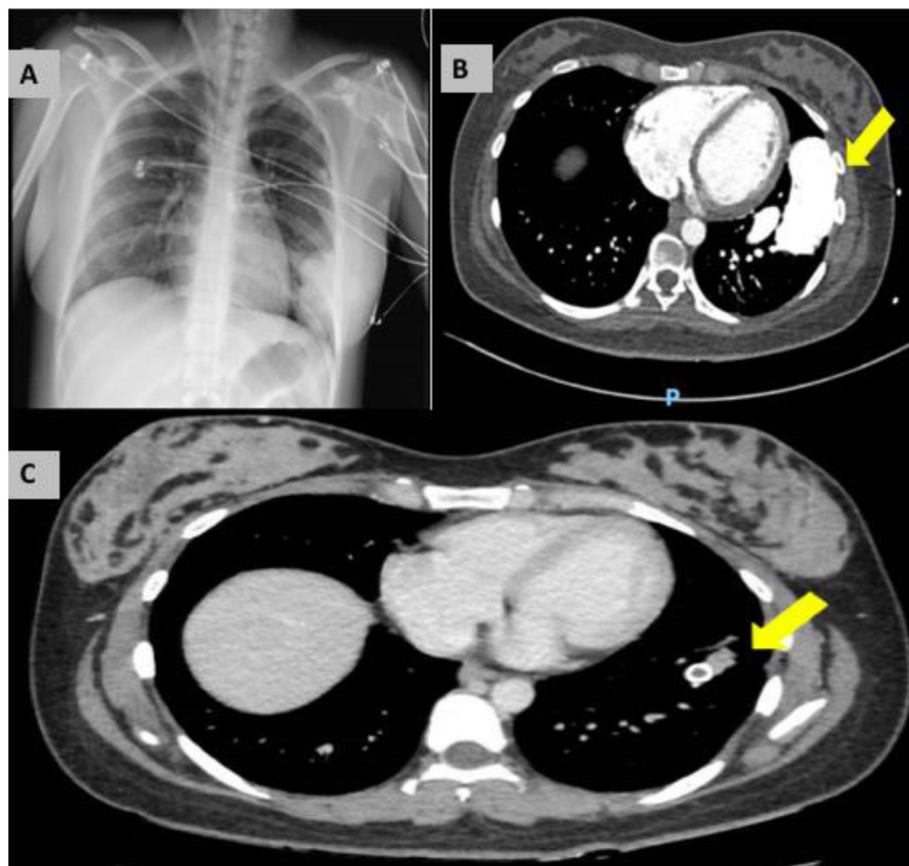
Chest X-ray showing an opacity in the left lower lobe. (B) Computed tomography angiography before endovascular embolization. The arrow indicates a large arteriovenous malformation in the left lower lobe. (C) Computed tomography angiography following endovascular embolization with an 18 mm Amplatzer. The arrow indicates post-embolization changes in the left lower lobe.
